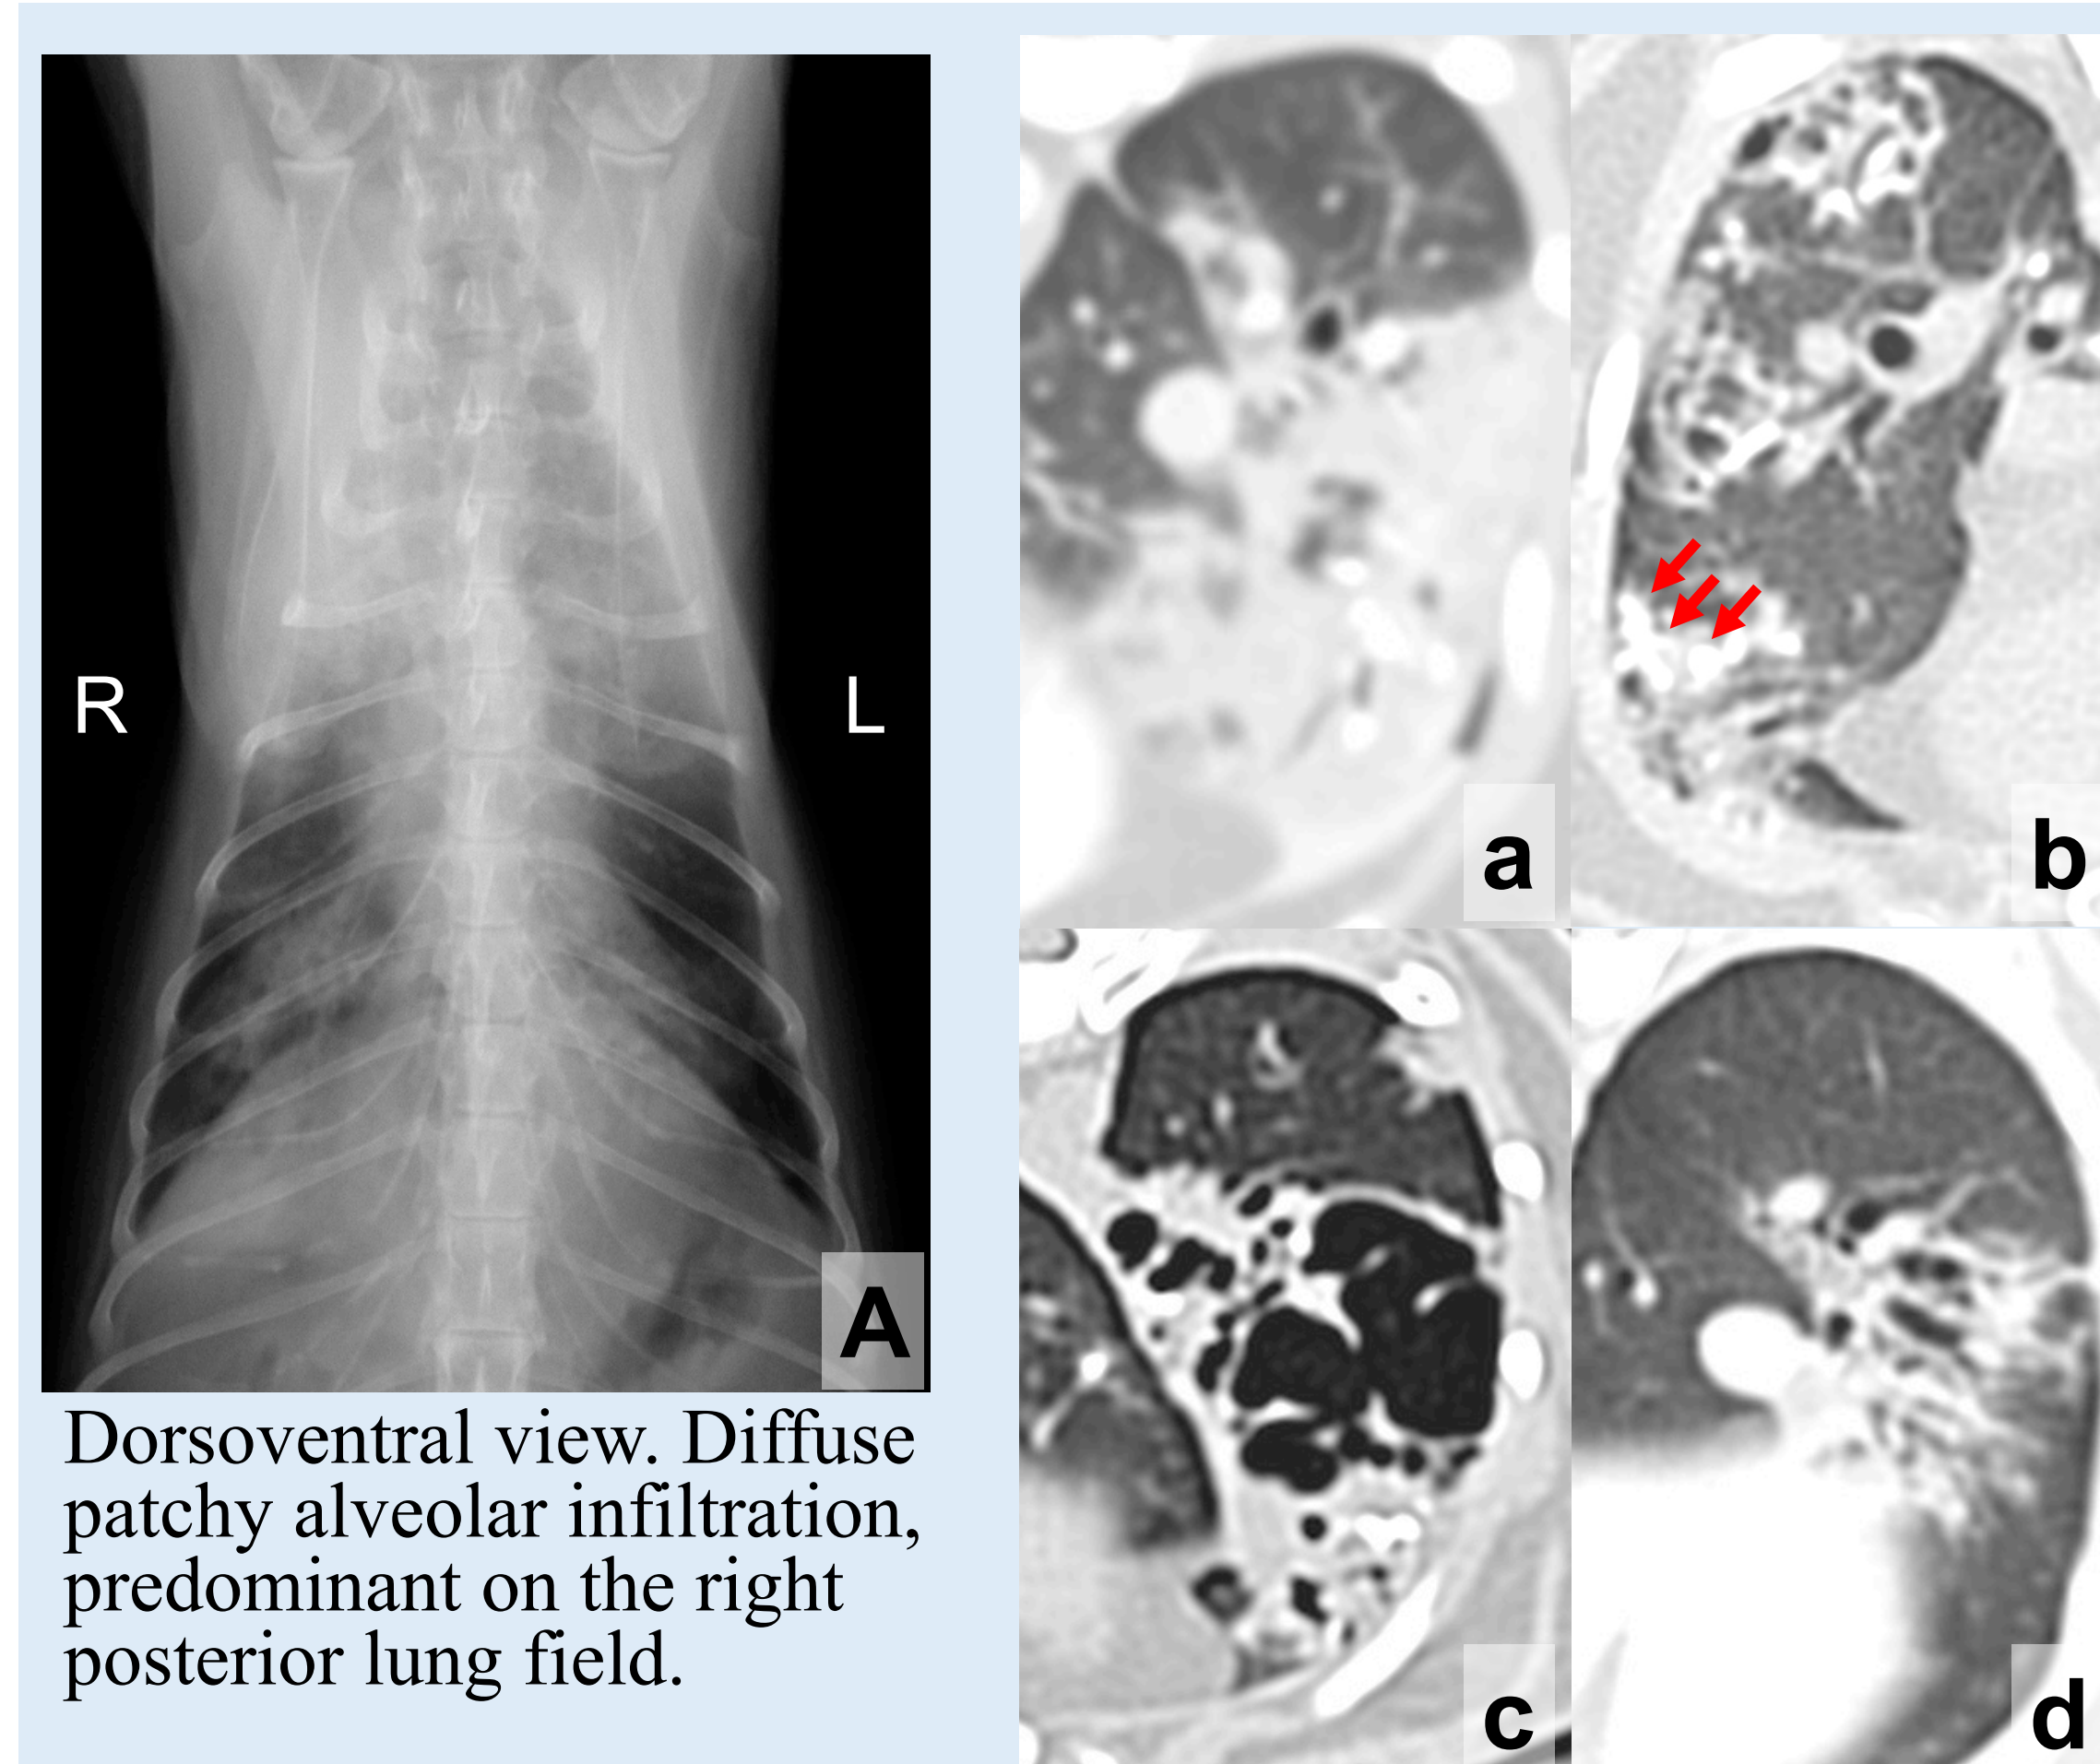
Chest X-ray and chest CT.
